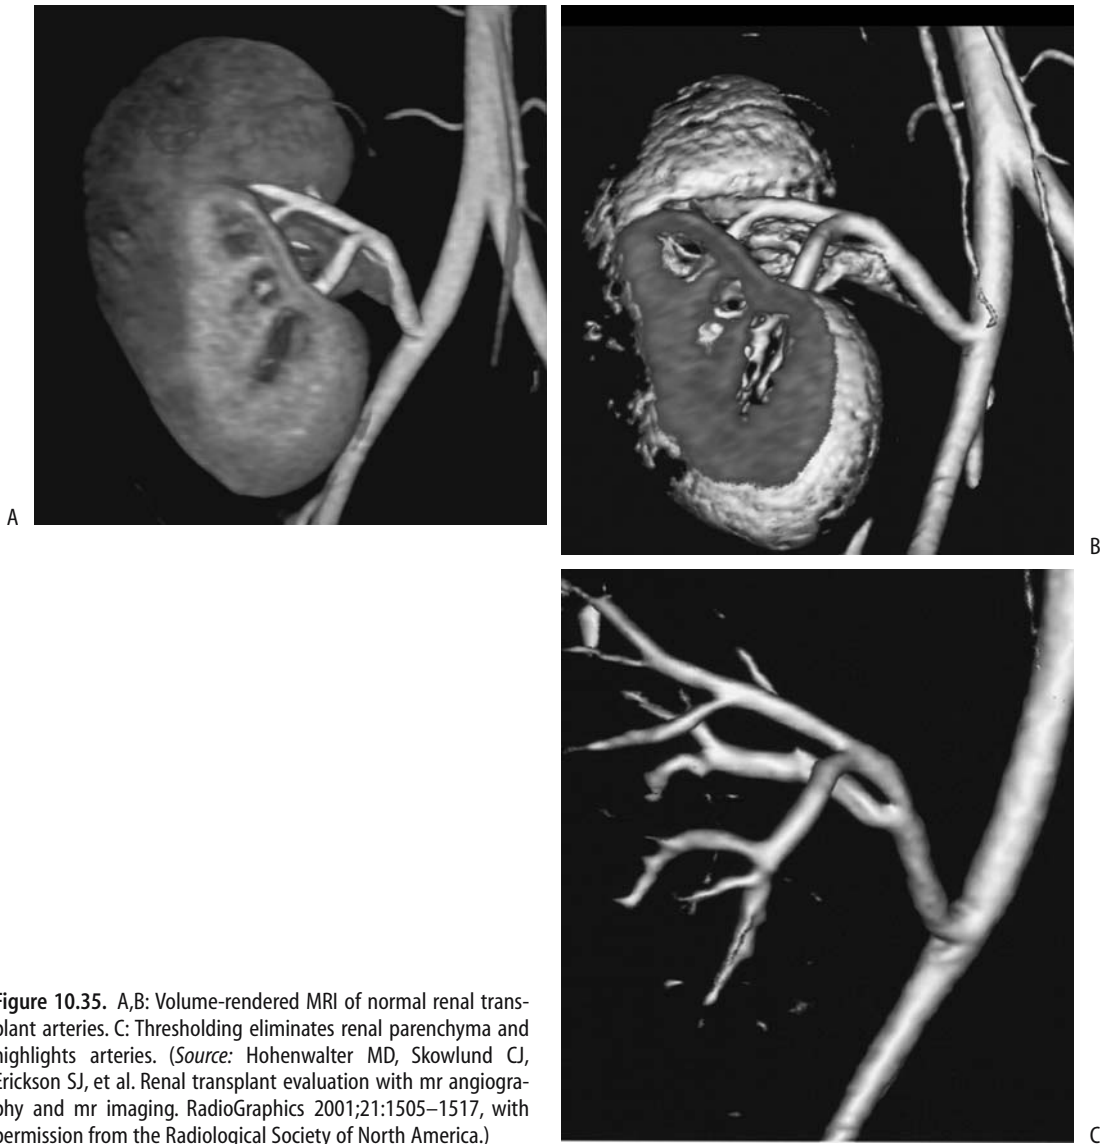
A,B: Volume-rendered MRI of normal renal transplant arteries. C: Thresholding eliminates renal parenchyma and highlights arteries. (Source: Hohenwalter MD, Skowlund CJ, Erickson SJ, et al. Renal transplant evaluation with mr angiography and mr imaging. *RadioGraphics* 2001;21:1505–1517, with permission from the Radiological Society of North America.)
